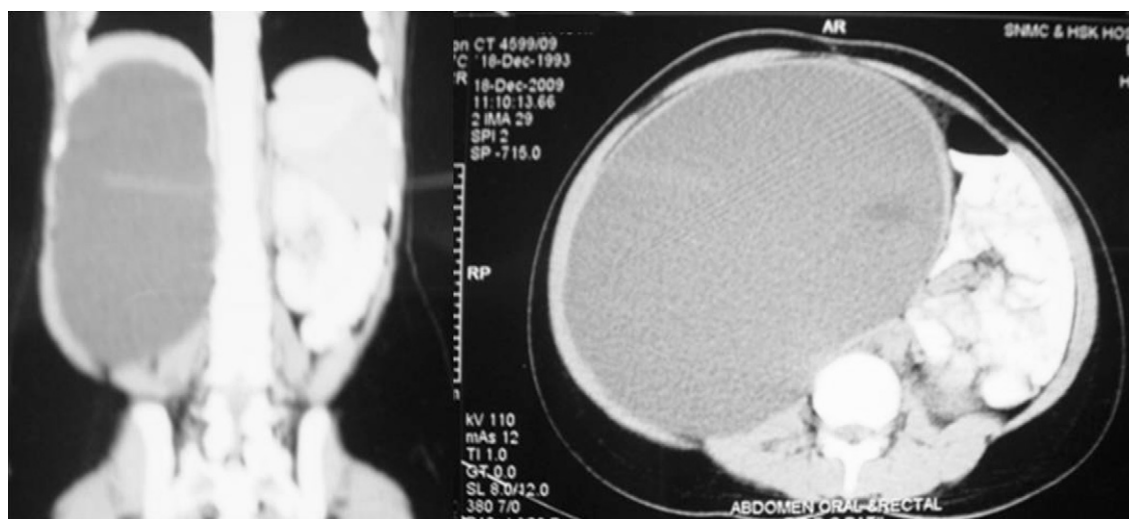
CT of abdomen showing right-side giant hydronephrosis with very thin renal parenchyma.
